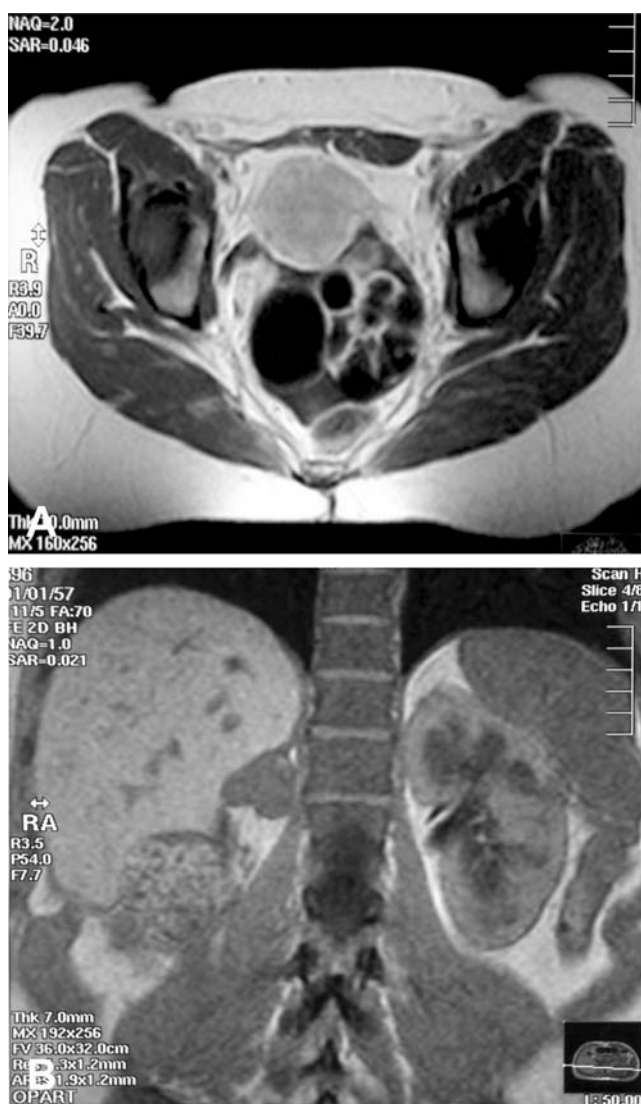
a Abdomen computed tomography scan: Cystic formation (8 cm in diameter) in the lower pelvis, between the uterus and the rectum. b Abdomen magnetic resonance imaging: Mass of non-homogeneous texture ($3 \times 2.5 \times 3$ cm) in the area of the right suprarenal gland
